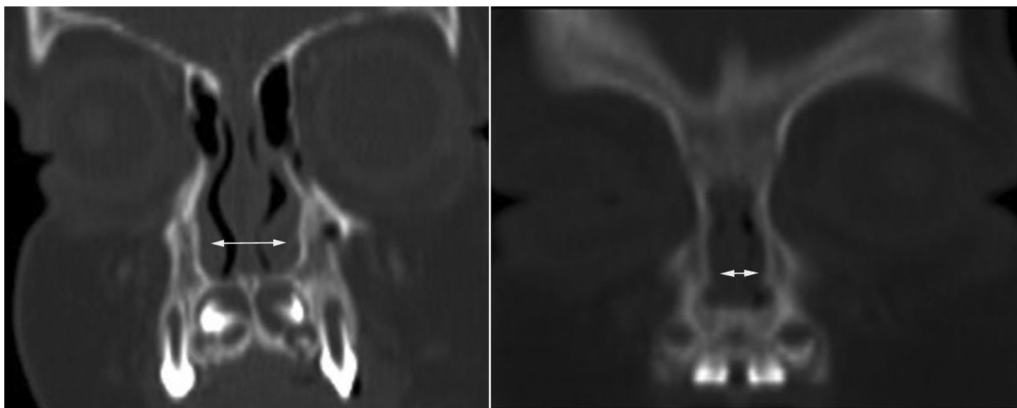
Coronal CT image showing normal width of the pyriform aperture in a 9-month-old female (left image). Compare to coronal CT image showing CNPAS in another 9-month-old female (right image).
